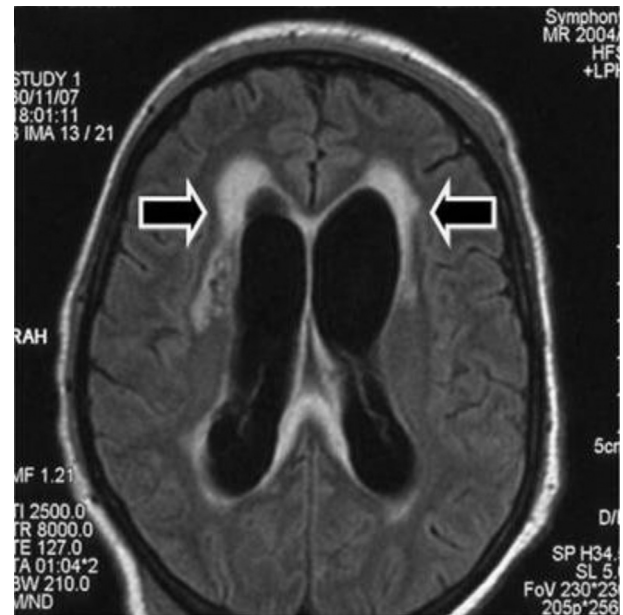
Magnetic resonance image demonstrating bilateral ventricular ependymal contrast enhancement indicative of ventriculitis (arrows).
